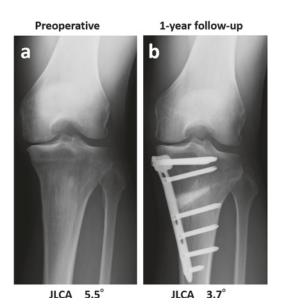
a Preoperative and b 1-year follow-up radiograph as a representative case. The JLCA decreased from 5.5° preoperatively to 3.7° at 1-year follow-up
